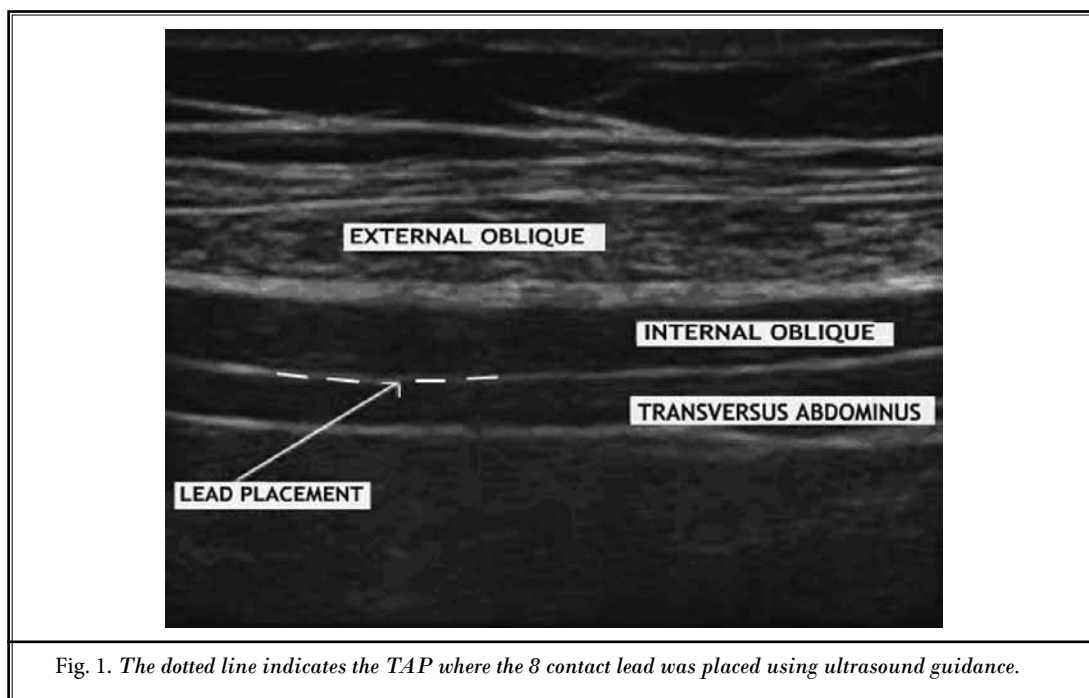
The dotted line indicates the TAP where the 8 contact lead was placed using ultrasound guidance.
